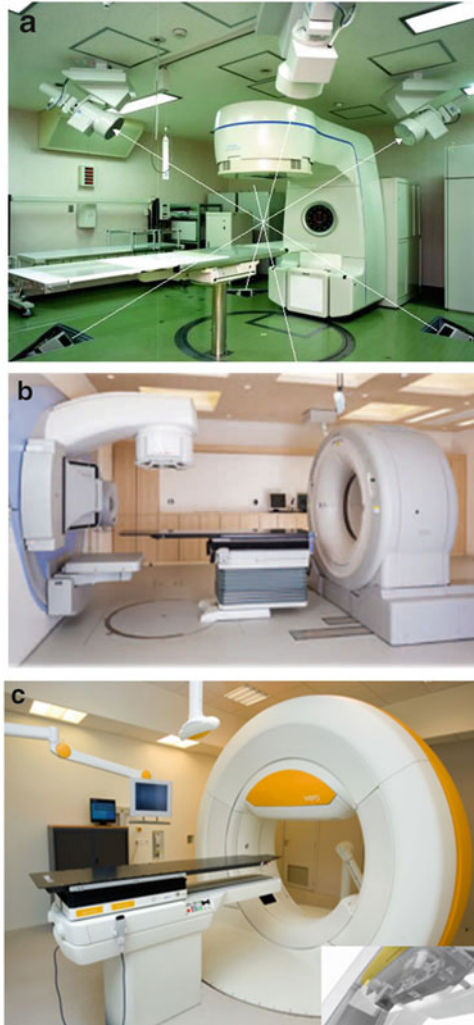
(a) Real-time tumor-tracking (RTRT) system (Shimadzu Inc.). (b) CT-on-rails system (ELEKTA Inc, Toshiba Medical Inc.). (c) Vero 4DRT (Mitsubishi Heavy Industry Inc.). Tumor tracking system using fiducial marker and a linear accelerator equipped with gimbal function. (d) CyberKnife G4 (Accuray Inc.) Method of fiducial-less tracking
